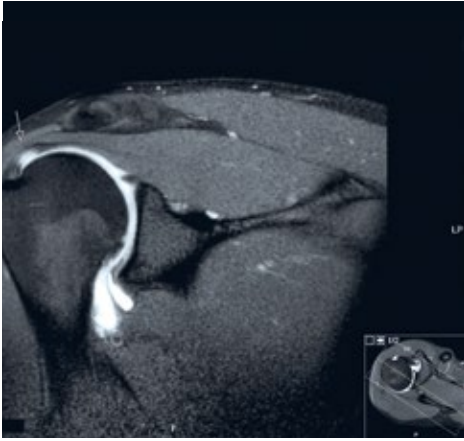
Example of a partial cuff tear (arrow) (oblique coronal orientation, T1-weighted): defect of the m. supraspinatus on the articular side
